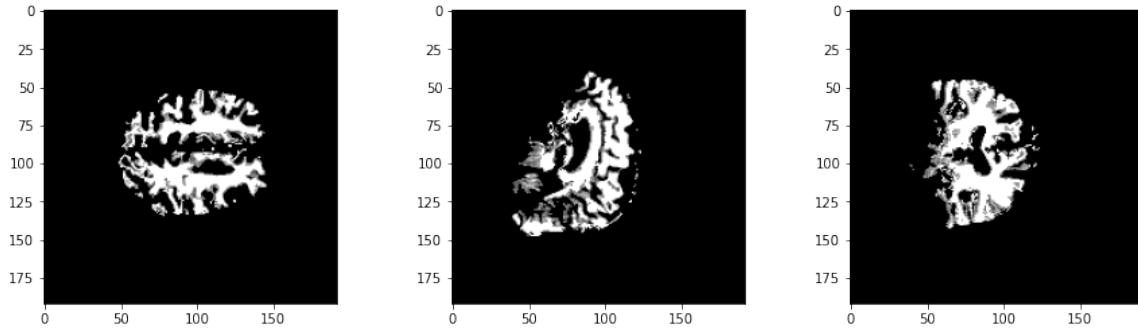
Preprocessed 3 Planes of the MRI image
